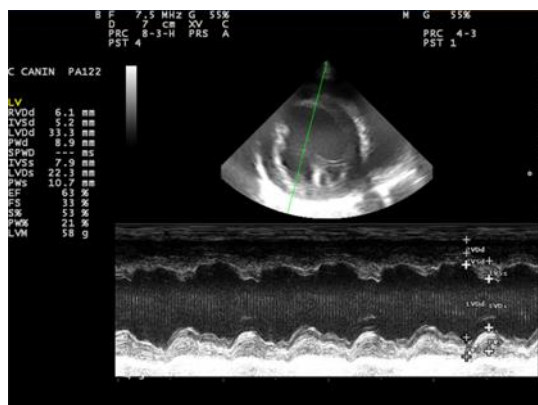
M-mode echocardiographic finding showing normal ejection fraction (EF)
